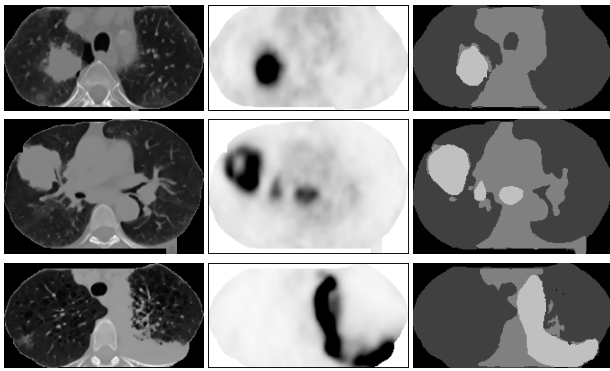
Three examples of ROI detection, showing one transaxial slice pair per patient study. The left column is the CT image slice (after preprocessing); the middle column is the co-registered PET slice; and the right column is the classification output.
